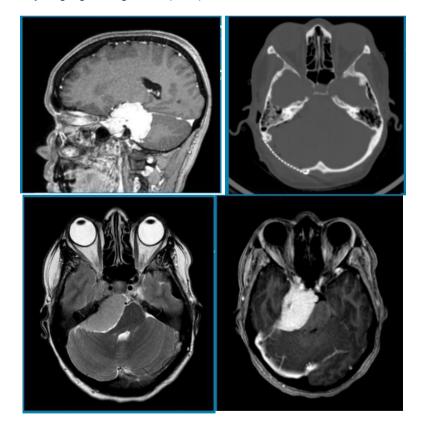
Clinical case: Female patient, 46 years old, presented with a headache with a different pattern than usual, in addition to mild right hearing loss. Skull Magnetic Resonance Imaging (MRI) showed an expansive lesion in the petroclival region on the right, suggestive of meningioma. The approach was performed using a retrosigmoid approach, with subsequent cranioplasty with a titanium plate
